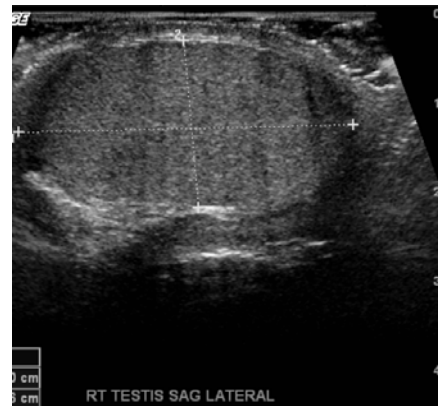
Grey scale ultrasound image of a normal-size right testicle.
